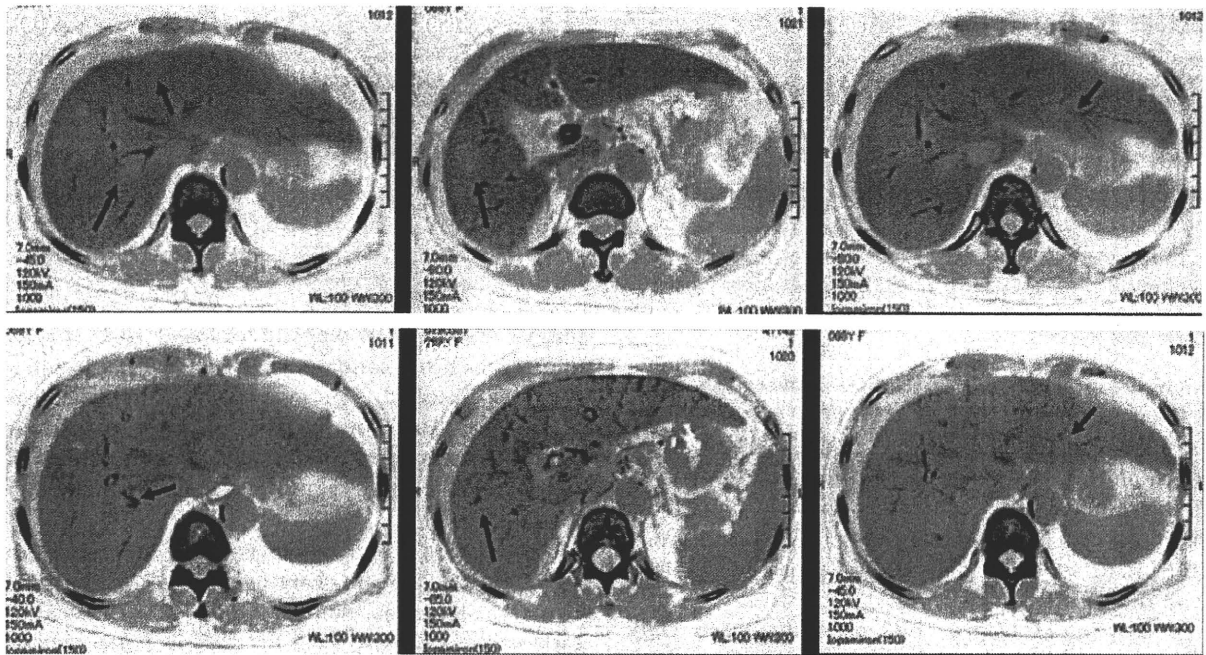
Findings of (a1–a3) computed tomography (CT) during arterial portography (CTAP) and (b1–b3) CT during hepatic arteriography (CTFA) in February 2006. (a1–a3) Four small liver nodules (all < 2.0 cm in diameter) were observed as attenuated nodules (low-density areas), three of which contained a small area of increased attenuation (arrows). (b1–b3) Minute high-density areas were observed that corresponded to the areas of increased attenuation on CTAP images, except in one tumor (arrows).
